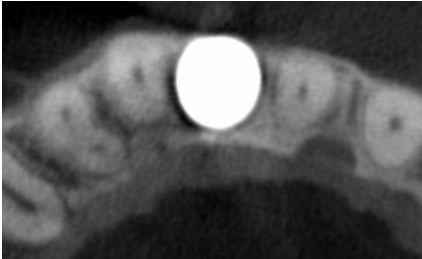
The axial CBCT slice confirms the oversized diameter of the implant filling almost the entire edentulous space
